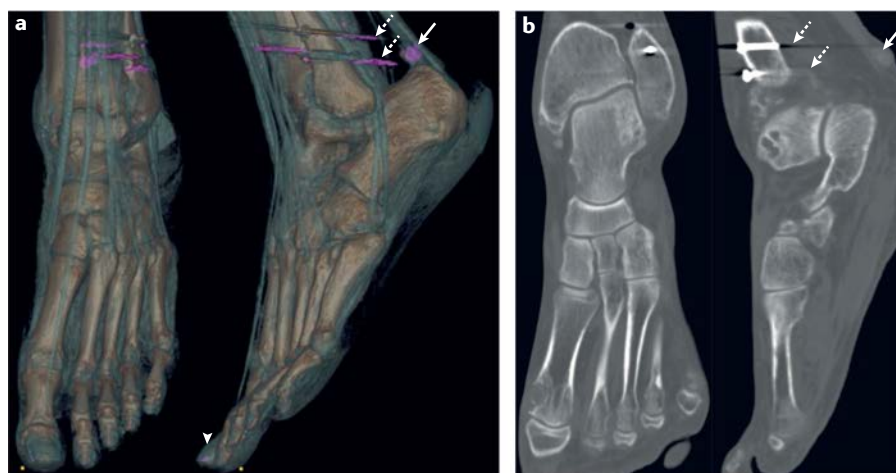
True-positive, false-positive and false-negative imaging findings for MSU deposition in a 68-year-old man with tophaceous and erosive gout. Dual-energy CT (DECT) (a) and coronal and sagittal conventional CT (b) images show monosodium urate (MSU) deposition in pink. The subcutaneous tophus (arrow) corresponds to true MSU (true-positive). Typical DECT artefacts also appear pink (false-positives), including artefacts related to metal screws (dashed arrows) and pseudo-MSU deposition (arrowhead). Notably, DECT failed to identify subtle MSU deposition within a typical gouty bone erosion in the first metatarsal bone, which was confirmed through joint and tophus aspiration (false-negative). Images in parts a and b courtesy of F. Becce, Lausanne University Hospital, Switzerland.
